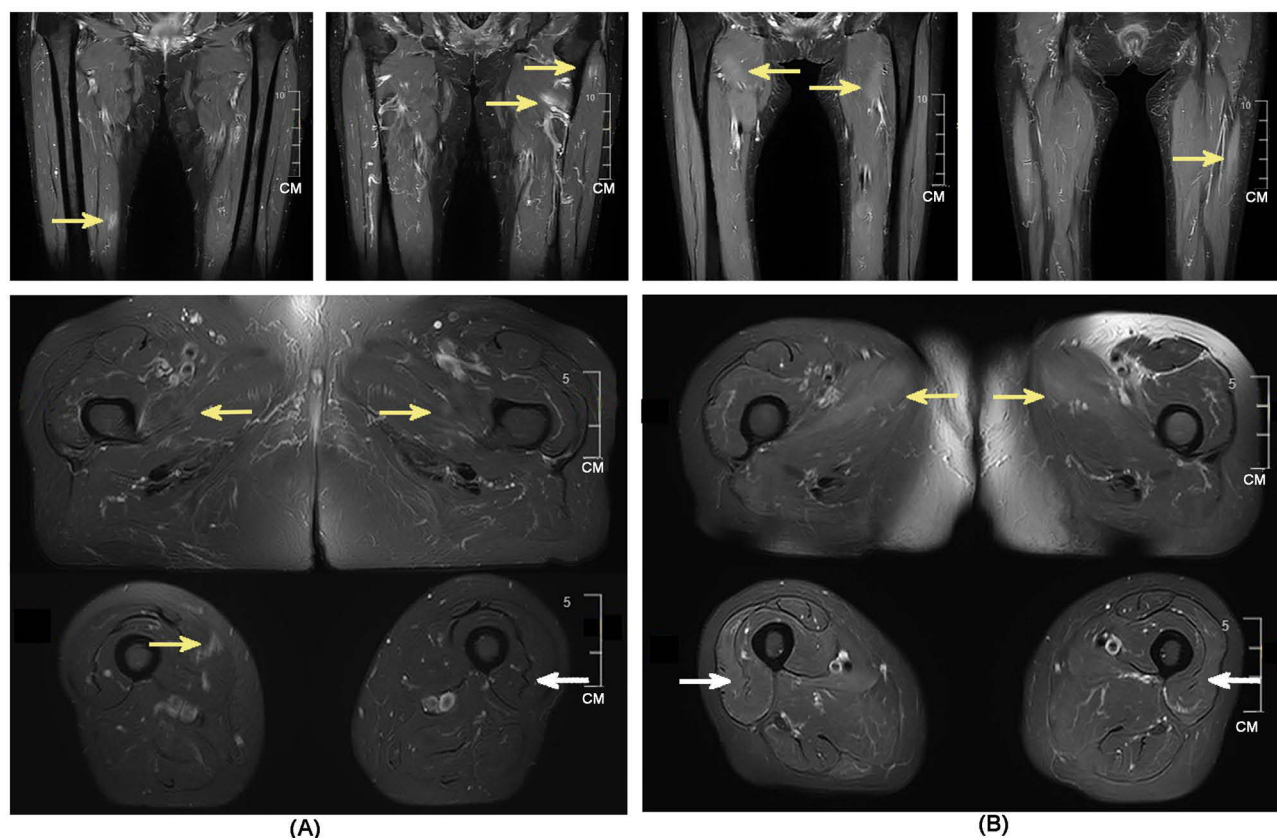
Thigh MRI T2-Weighted Fat-Suppressed Sequences (A) Patient 2: Axial view demonstrates patchy hyperintensities in the quadriceps femoris, more prominent on the left side (yellow arrows), with M-shaped fascial changes (white arrows). CM, centimeter. (B) Patient 6: Axial view reveals bilateral quadriceps femoris with roughly symmetrical patchy hyperintensities (yellow arrows) and M-shaped fascial changes (white arrows). CM, centimeter.
